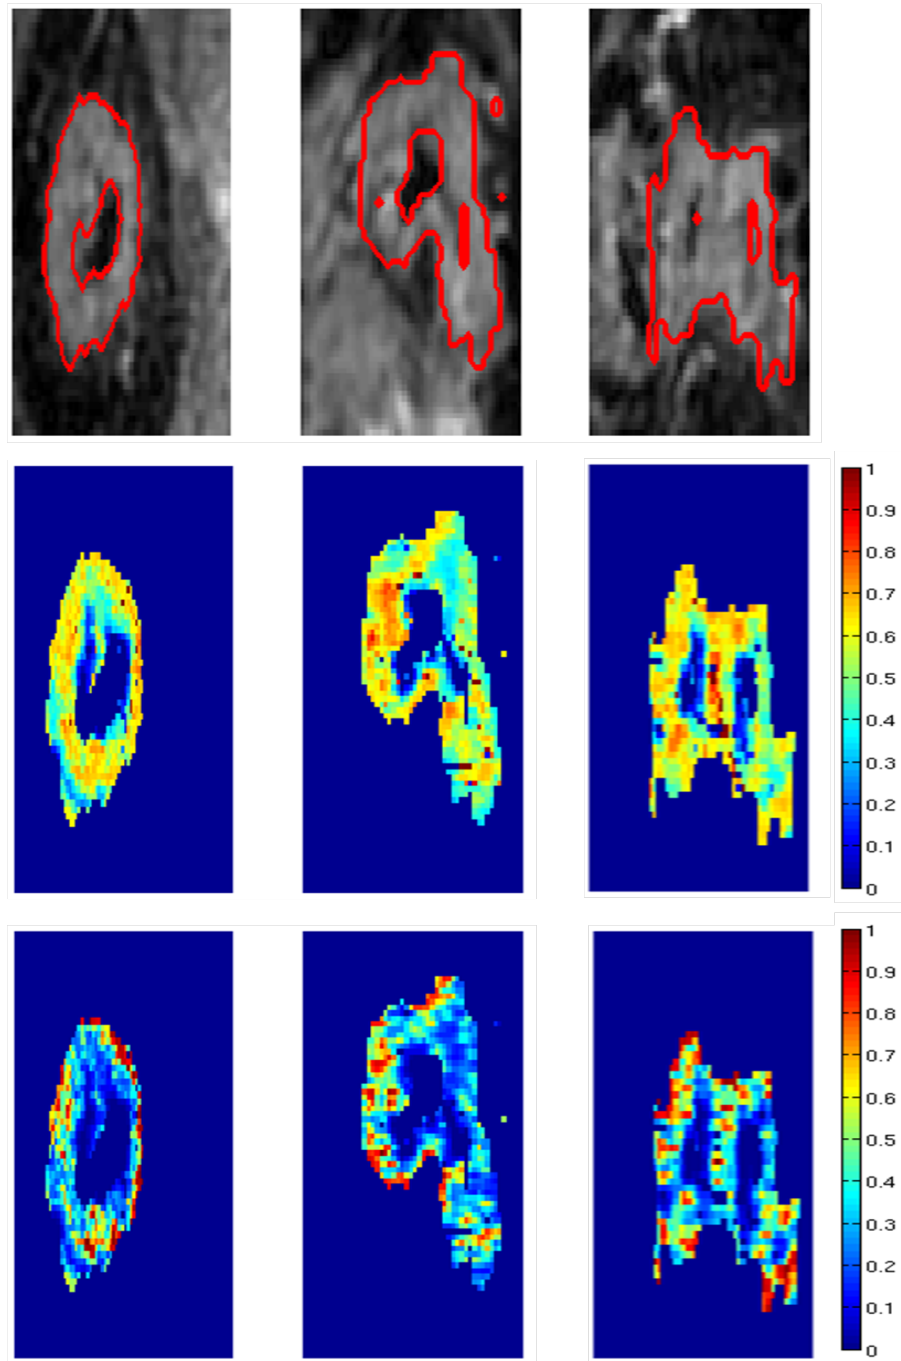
The tumour outline on the pre-contrast DCE-MRI image (top), the K^{trans} map in min^{-1} (middle) and a ratio of the K^{trans} map with the map of onset times in min (bottom) for a rectal adenocarcinoma of a non-responding patient.
